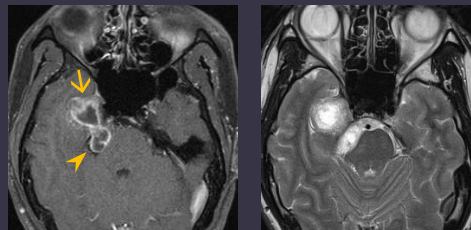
MRI T1 FS + C (Left) & T2 (Right)
